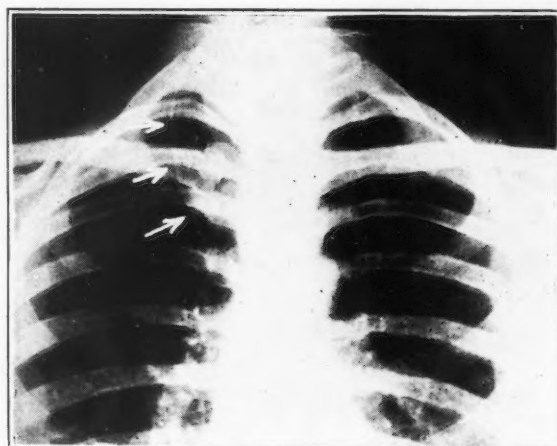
(Case 2). Age 33. Referred for roentgen examination of heart. No important chest findings. Arrows indicate pleural reflection of azygos lobe.
